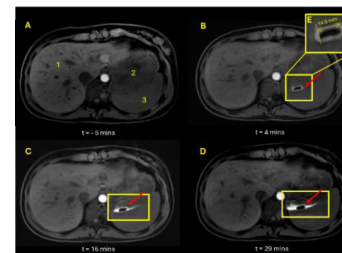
Axial, 3D LAVA MRI images of abdomen. Image A shows image after administration of nutritional drink and prior to tablet administration. Image B, C, D show tablet at time points 4, 16 and 29 minutes, respectively, post tablet administration with inset E showing an enlarged image of tablet. Anatomical landmarks indicated in image A, liver(1), stomach(2), spleen(3).
